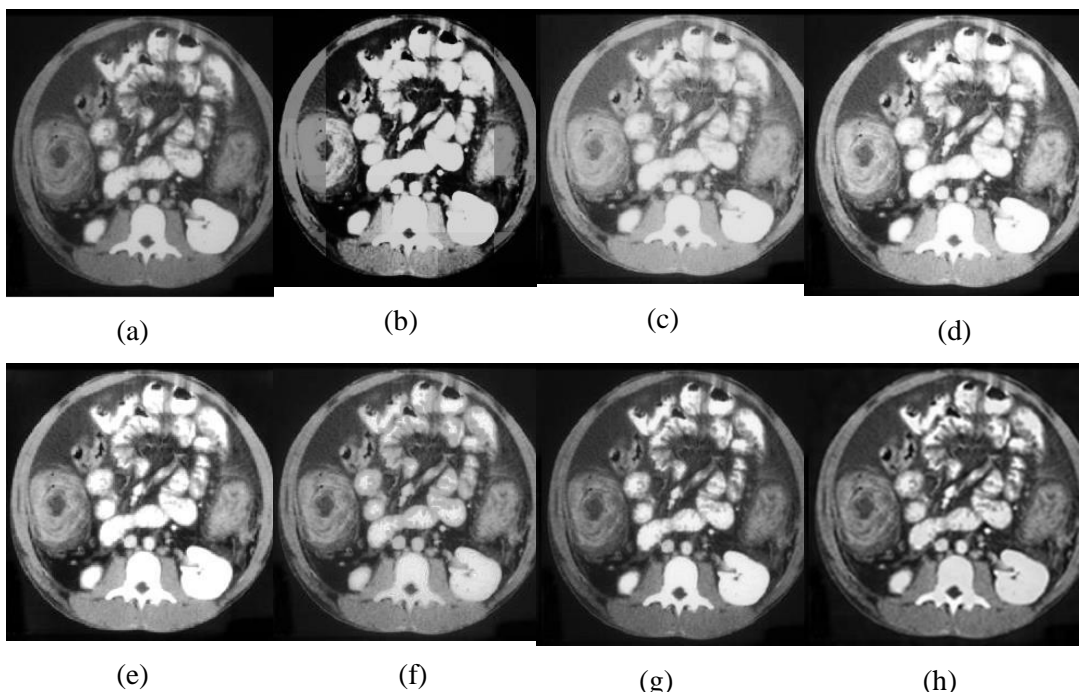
4.12 Experiment outcomes of the 'CT-5' Image (a) Original image, (b) S-curve, (c) AGC-DWT, (d) AGC-WHD, (e) GAGC-DWT, (f) EBCHE, (g) TCHE-DWT, (h) Proposed scheme
